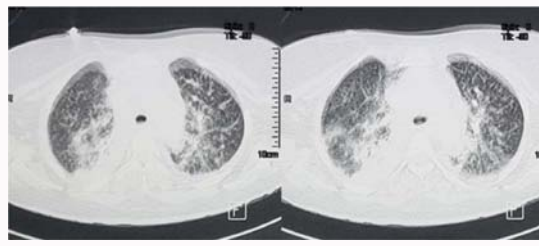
CT scan of the lungs showing alveolar consolidation with air bronchograms.
